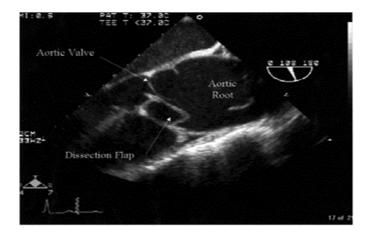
Transesophageal echocardiographic image of the long axis of the ascending aorta demonstrating a type I acute aortic dissection with the dissection flap prolapsing through the aortic valve. This results in significant aortic insufficiency due to an abnormality of valve leaflet coaptation.
